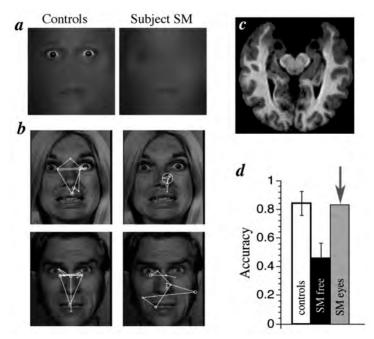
Abstract Functions of the Amygdala Contribute to Social Perception. Bilateral amygdala lesions impair the use of the eyes and gaze to the eyes during emotion judgment. (a) A patient with bilateral damage to the amygdala made significantly less use of information from the eye region of faces when judging emotion. (b) While looking at whole faces, the patient (right column of images) exhibited abnormal face gaze, making far fewer fixations to the eyes than did controls (left column of images). This was observed across emotions (free viewing, emotion judgment, gender discrimination). (c) MRI scan of the patient's brain, whose lesion was relatively restricted to the entire amygdala, a very rare lesion in humans. The two round black regions near the top middle of the image are the lesioned amygdalae. (d) When the subject was instructed to look at the eyes ("SM eyes") in a whole face, she could do this, resulting in a remarkable recovery in ability to recognize the facial expression of fear. The findings show that an apparent role for the amygdala in processing fearful facial expressions is in fact more abstract, and involves the detection and attentional direction onto features that are socially informative. Modified from (Adolphs et al 2005).
